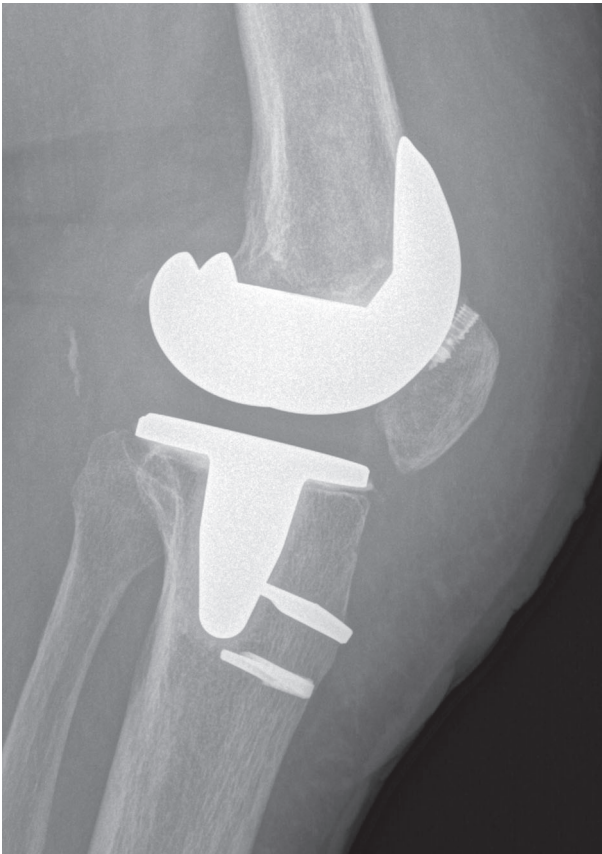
X-Rays showing primary quadriceps reconstruction with suture anchors at the superior pole of the patella, and tibial fixation of the LARS ligament with two staples
